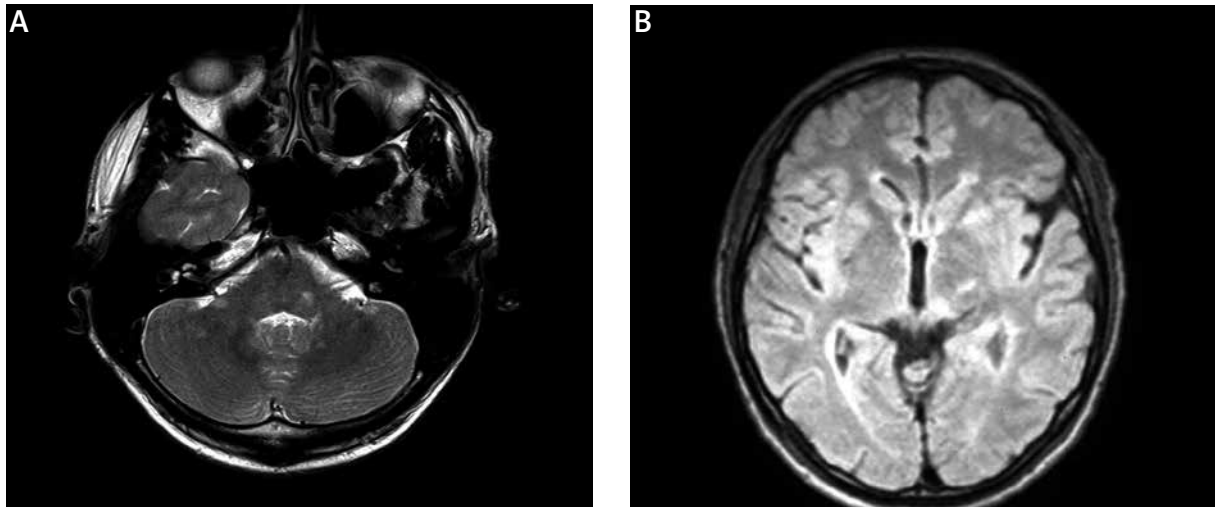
Case 2. A) Axial FLAIR and B) T2 MR images demonstrate demyelinating lesions in the cerebellum, left thalamus and periventricular area.
